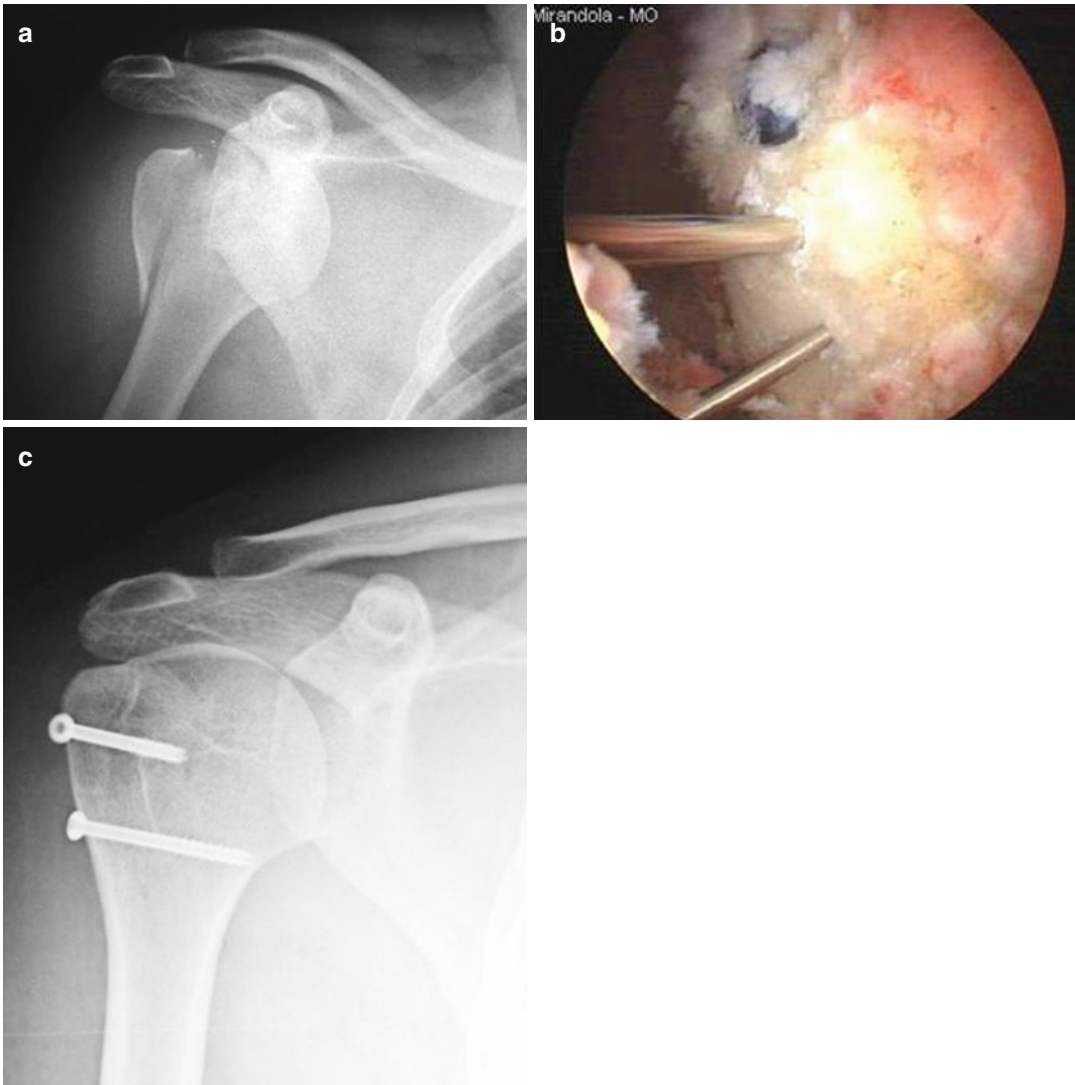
(a) Single large fragment of greater tuberosity fracture: X-ray. (b) Arthroscopic treatment with two cannulated screws. (c) Postoperative X-ray
